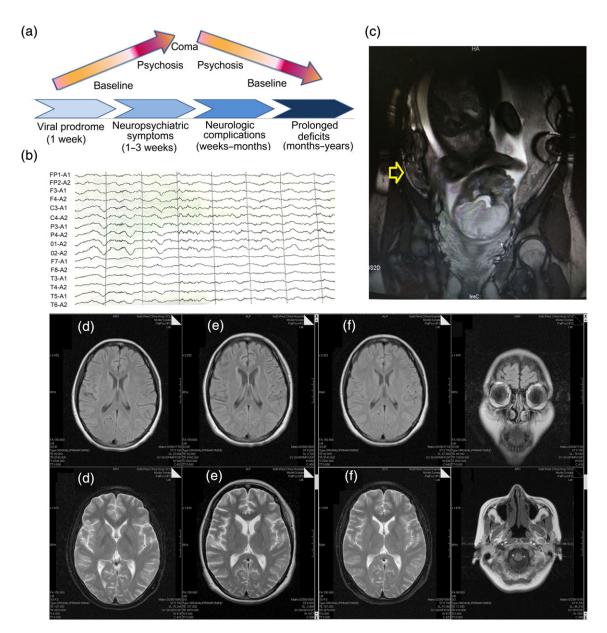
Symptoms and auxiliary examination in a patient with anti-N-methyl-D-aspartate receptor (anti-NMDA-R) encephalitis. (a) Four steps of anti-NMDA-R encephalitis. (b) Abnormalities revealed by electroencephalogram (EEG) records. EEG showed slow and disorganized activity in the delta/theta range, sometimes with superimposed electrographic seizures. (c) A magnetic resonance image (MRI) of the abdomen and pelvis did not reveal any ovarian cyst (arrow indicates one side of ovary). (d) The results of brain MRI were unremarkable at the precursor stage (viral prodrome). (e) Follow-up MRI was performed to exclude brain stroke (venous sinus thrombosis) or other encephalitis (neurologic complications). (f) The results of brain MRI were normal during the recovery period (prolonged deficits).
